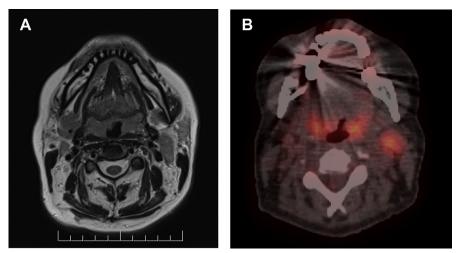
(*A*) MRI scan of patient presenting with large volume palatine and lingual tonsil tissue with suspicious primary site on the side of nodal disease. (*B*) PET/CT of the same patients showing PET avidity in the both palatine tonsils with mild asymmetric uptake on the side of the nodal disease.
